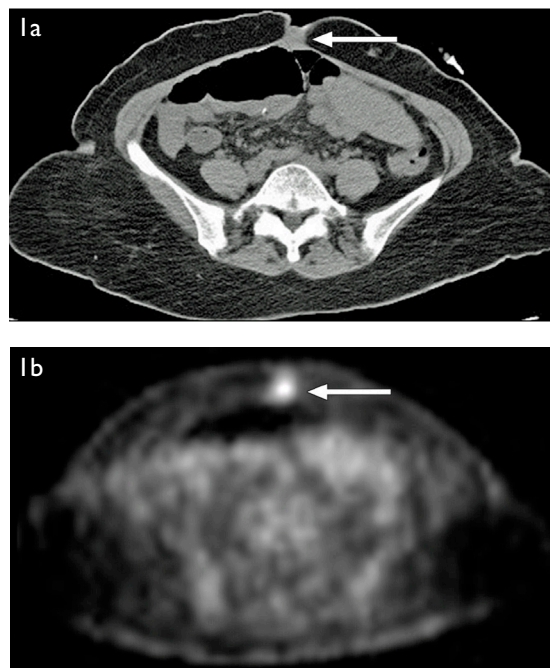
(a) Non-contrast-enhanced CT image shows a soft tissue nodule at the umbilicus (arrow). (b) F18-FDG PET-CT image shows that the umbilical nodule was markedly metabolic-avid (arrow), indicating an umbilical metastatic deposit.
